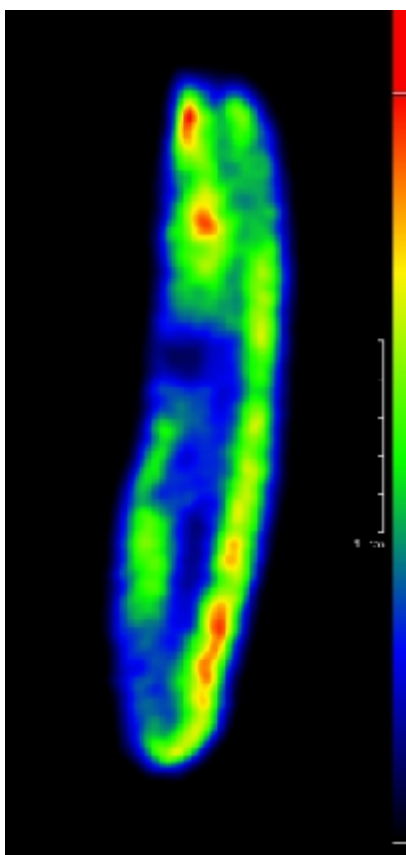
Organs of earthworm (*E. hortensis*) are visualized by nanoScan PET/MRI (Mediso Ltd, Hungary). T1 weighted spoiled gradient echo sequence, 3 dimensional acquisition scheme.
